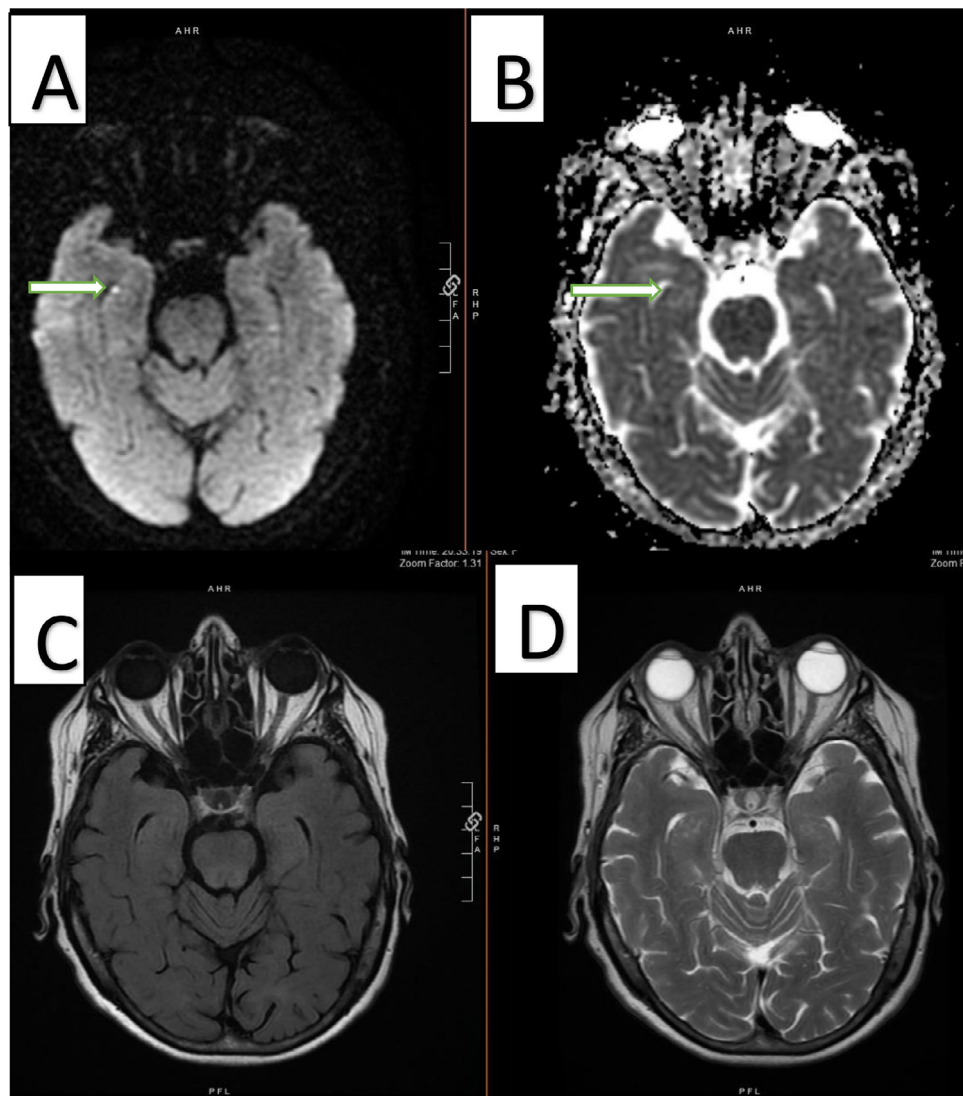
MRI Brain without contrast (A) DWI showing restriction in the right medial temporal lobe along with corresponding ADC (B) images (arrows), (C) FLAIR and (D) T2 sequence.
